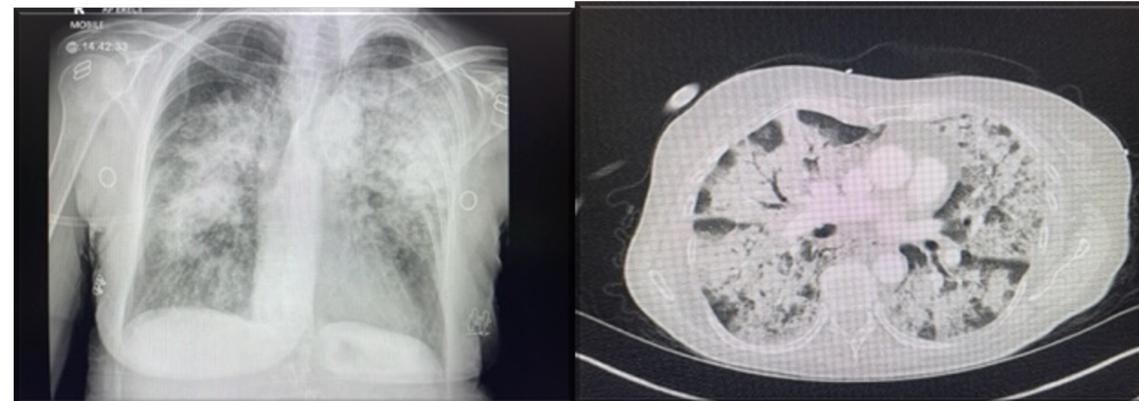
X-Ray on presentation Fig 2: Scan on presentation
